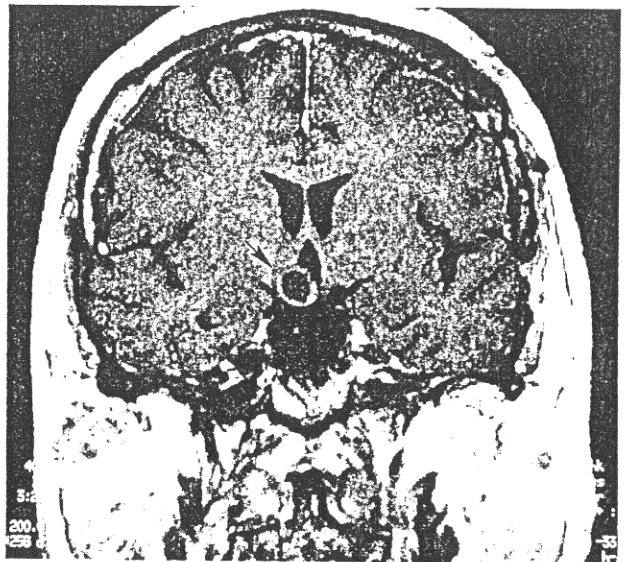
A: Preoperative sagittal MRI-scan of the case shown in Figs. 17–19. Position of tumor shown between arrows. B: Preoperative coronal MRI-scan. Arrow points to the tumor, partially within and partially outside the third ventricle.
